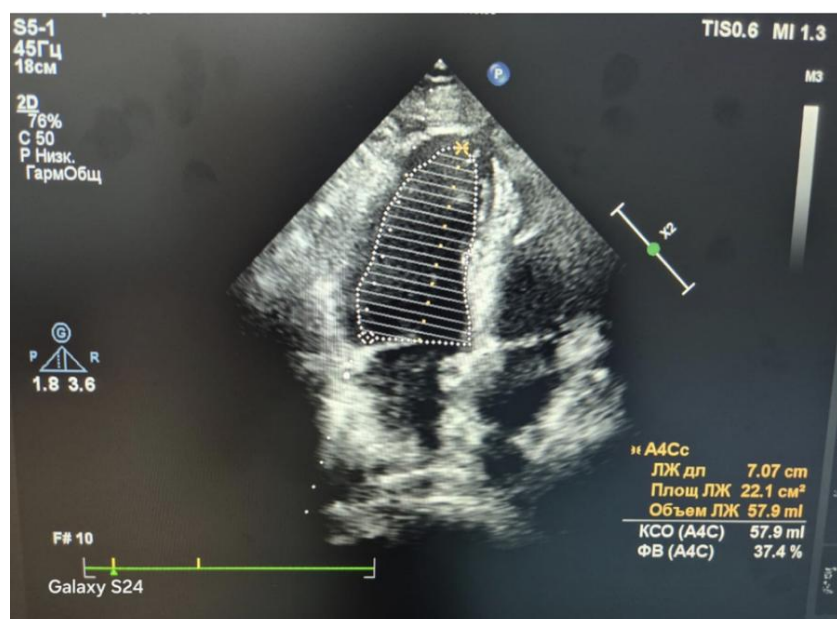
Cardiac ultrasound after three month of discharge. Dilation of both atria is observed, with a decrease in dynamics. Diffuse hypokinesia of all walls of the LV and RV. The global systolic function of the left ventricle and EF is significantly reduced to 38%, with improvement in dynamics. Mitral and tricuspid valve insufficiency of grade 1. Diastolic dysfunction of the left ventricle of type 1.
